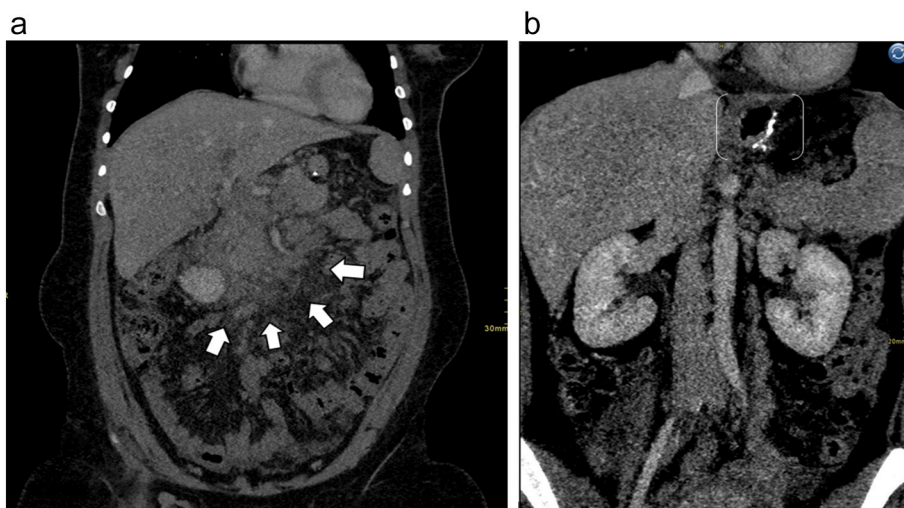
a. Contrast –enhanced CT abdomen at Porto venous phase coronal section demonstrating diffuse mesenteric engorgement with patent distal vessels is noted and stranding was seen predominantly at the mesenteric roots (Arrows).
